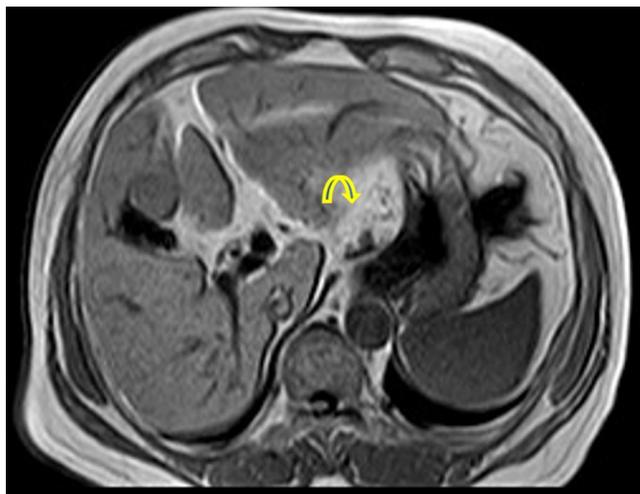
Hepatobiliary phase magnetic resonance imaging in 51-years-old women with cirrhosis other than hepatitis B or C. The arrow indicates hyperintensity.
